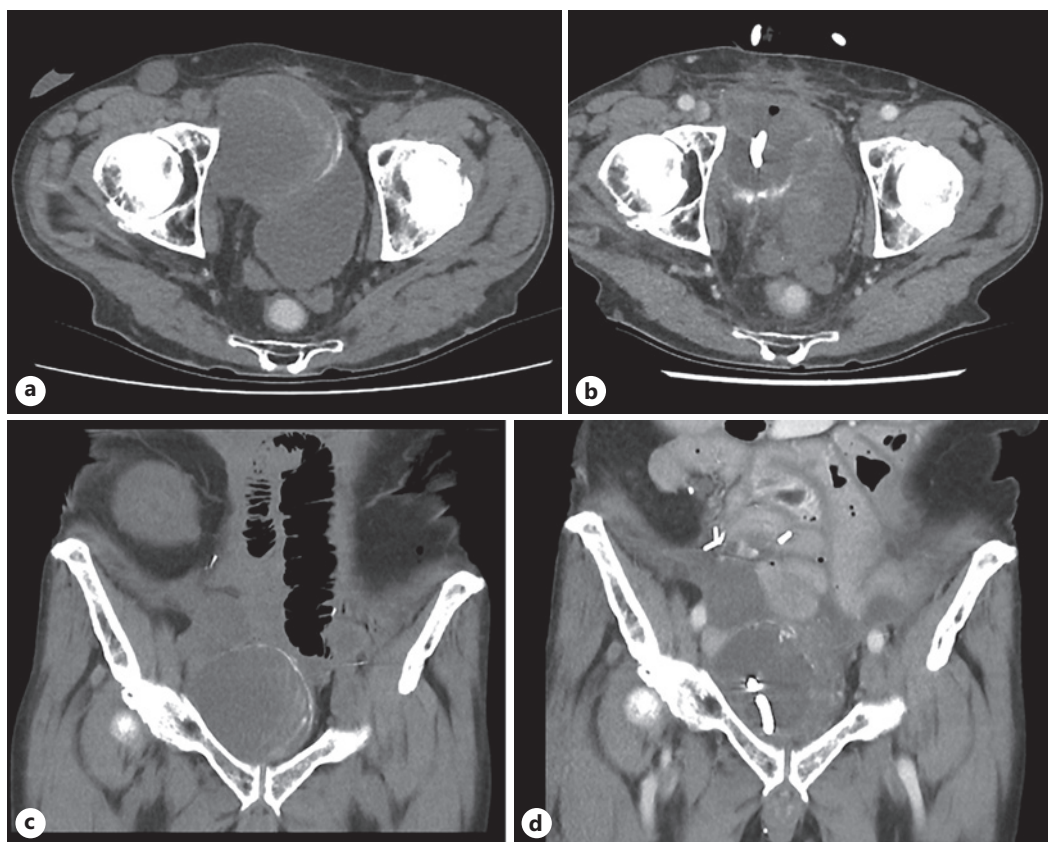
CT pre- and post-treatment. Progress scan on right (b, d). Multiple mild peripherally enhancing collections demonstrated within the pelvic, largest of which in the left posterior pelvic measures 80 × 39 mm trans-axially (previously 85 × 55 mm). The anterior pelvic collection has reduced in size with a pigtail tube in situ, now measuring 57 × 51 mm trans-axially (previously 71 × 69 mm). Scan 1: October 21, 2021, scan 2: October 13, 2021. CT, computed tomography.
